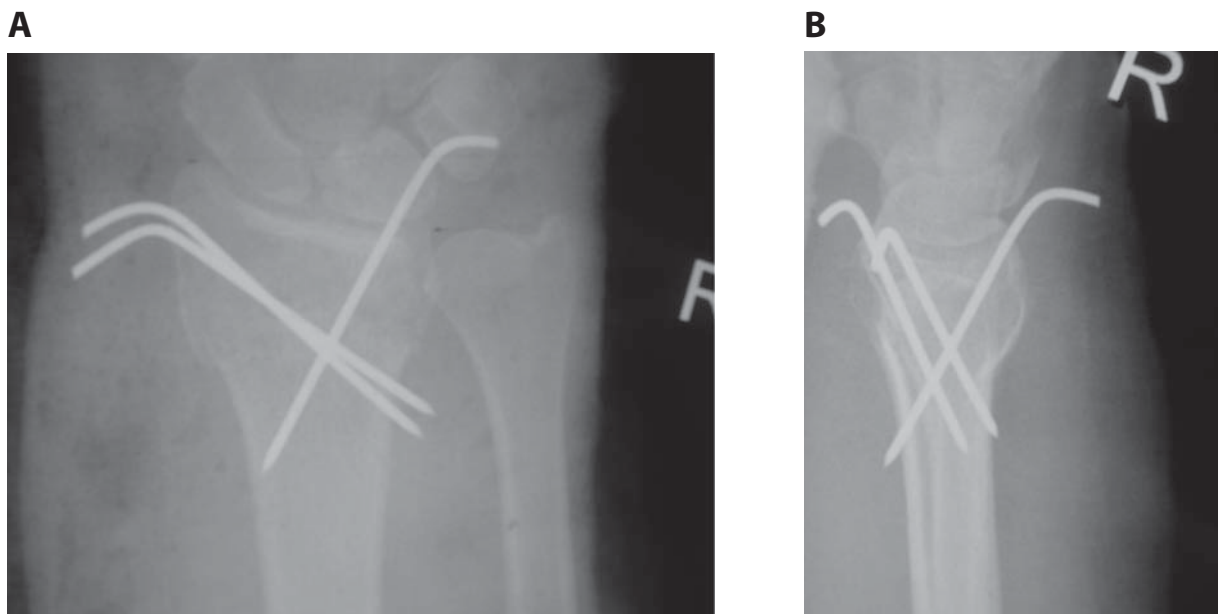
Post-surgery radiographic images of a fracture treated with Kirschner wires – antero-posterior (A) and lateral (B) views.
